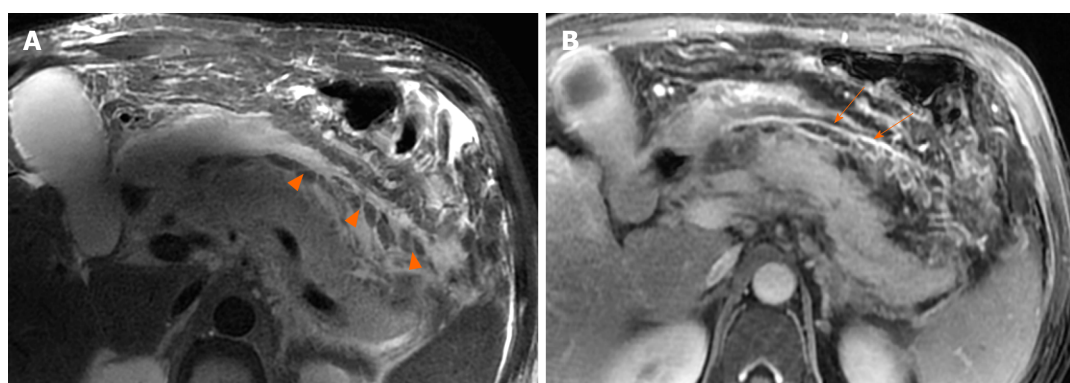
A 46-year-old man with necrotizing pancreatitis. A: Magnetic resonance imaging axial T2WI image shows a number of patchy, strip-shaped T2-hypointense components (necrotic adipose fragments) (arrowheads) among T2-hyperintense fluid; B: Axial contrast-enhanced magnetic resonance imaging shows viable capsule enhancement (arrows).
